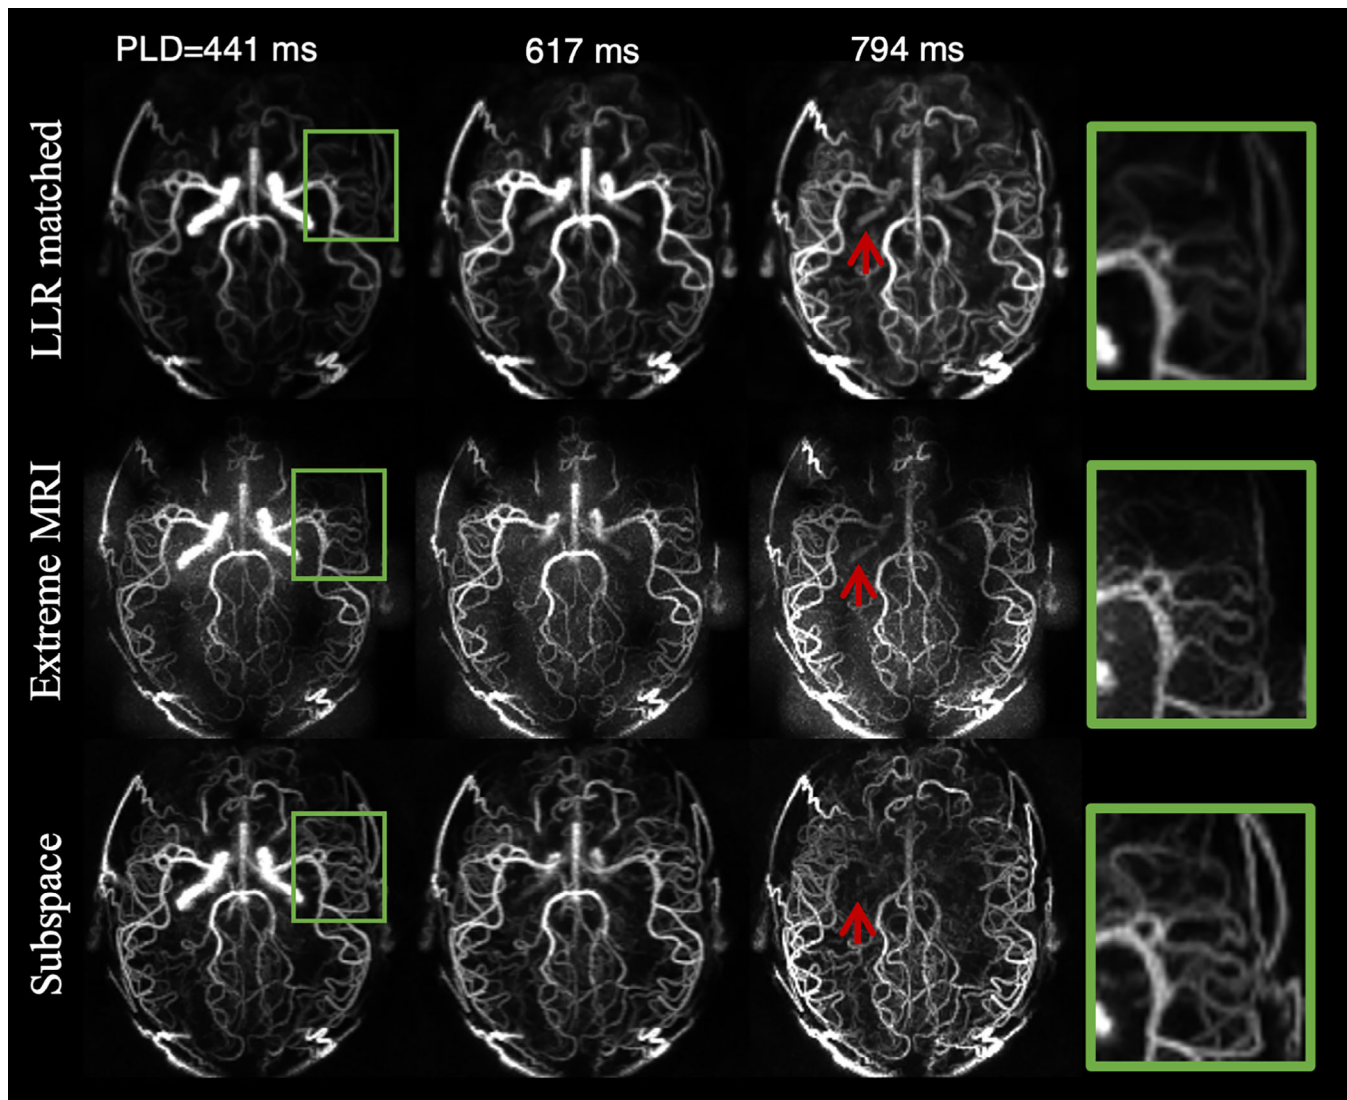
Comparison of subspace with other advanced reconstruction methods. LLR-matched adapted the temporal binning reconstruction to the same temporal resolution as subspace. Extreme MRI is a multi-scale low rank method and also had matched temporal resolution. Regions enlarged within the green box show loss of details in Extreme MRI and LLR-matched results, but better clarity in subspace. Red arrows highlighted falsely reconstructed arteries in LLR-matched because of regularization. Further investigation of the effects of regularization weight in Extreme MRI and LLR-matched is shown in Figures S1 and S2. LLR, locally low rank.
